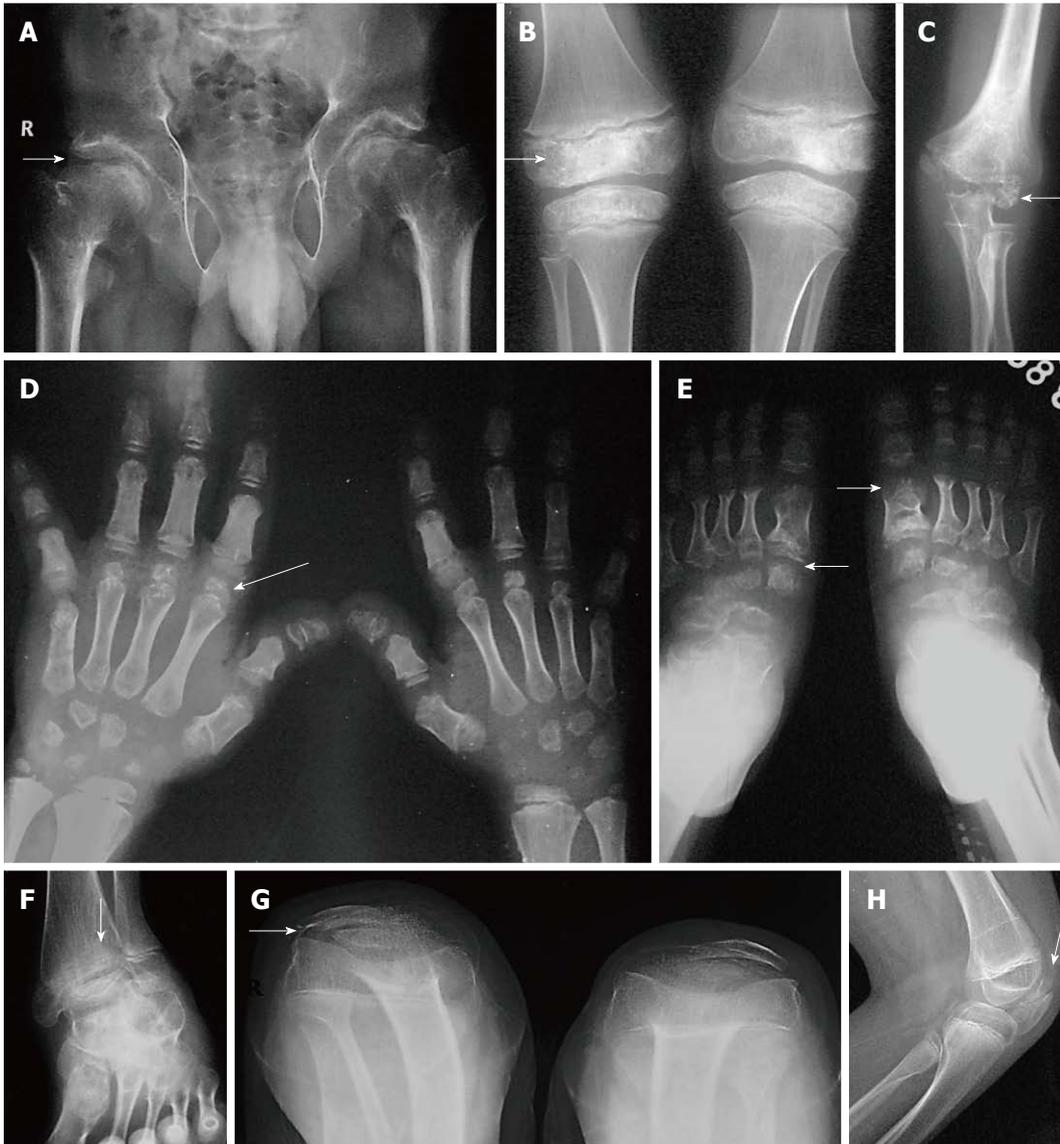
Multiple epiphyseal dysplasia. Radiographs of pelvis, knee and elbow (A-E) show epiphyseal irregularity in proximal femurs (arrow, A), around knee joints (arrow, B), elbow (arrow, C) with involvement of epiphyses of hands and feet (arrows in D, E) suggestive of multiple epiphyseal dysplasia. Radiograph of ankle (F) shows lateral tibio-talar slant. Radiograph of bilateral knees skyline view (G) and lateral view of left knee (H) show double-layered patellae (arrows).
